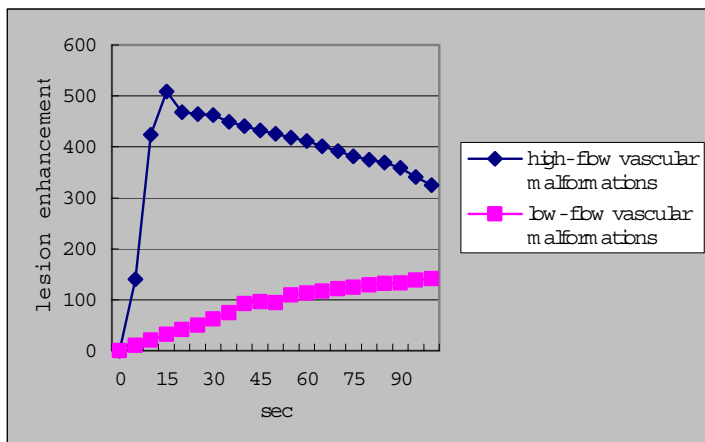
Graph shows changes in the mean lesion enhancement ratio with each type of vascular malformations on dynamic contrast-enhanced MR imaging.
